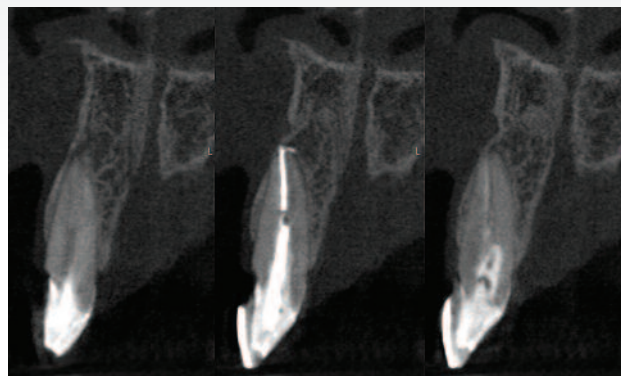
Preoperative CBCT scans of tooth 21.
